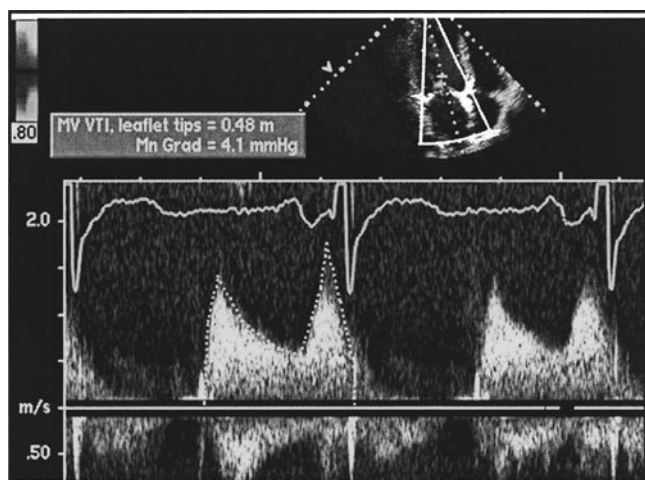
Continuous-wave Doppler in the same patient as in Fig. 11-13 after commissurotomy. The mean gradient is now low, with rapid deceleration of early diastolic velocity consistent with mild MS.
